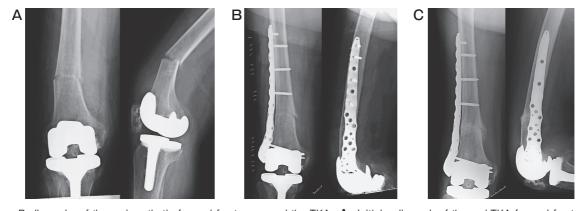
Radiographs of the periprosthetic femoral fracture around the TKA. A, Initial radiograph of the peri-TKA femoral fracture. The fracture line was consistent with the tracker pin hole; B, Postoperative radiograph. A periprosthetic locking plate was used; C, Radiograph 3 months after the surgery. Bone union was achieved.
